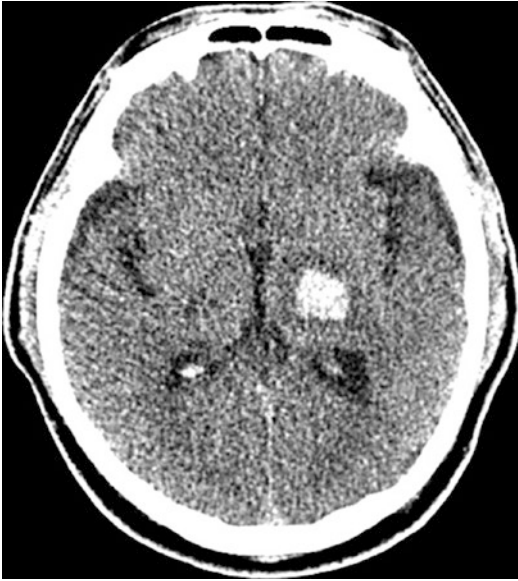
A 60-year-old hypertensive man developed dysarthria, right hemiparesis, and severe sensory deficits. CT showed a thalamic hemorrhage of posterolateral type (Fig. 8.6c)
